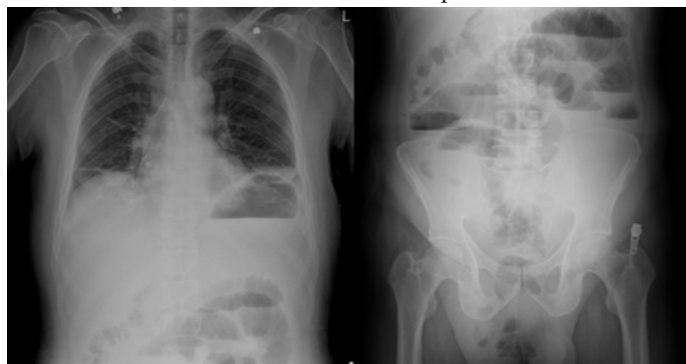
Multiple air-fluid levels seen in erect abdominal X-ray film.
